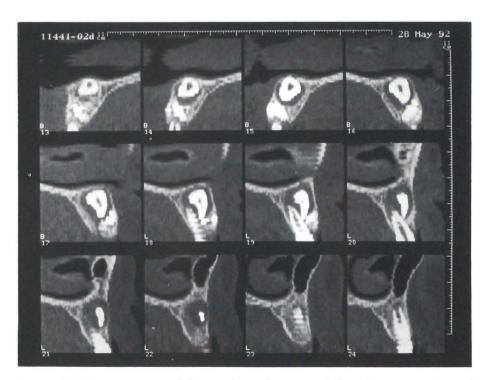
CT reconstruction of the maxilla at a buccopalatal plane demonstrates in serial cuts that tooth #21 has only crown and no root.
